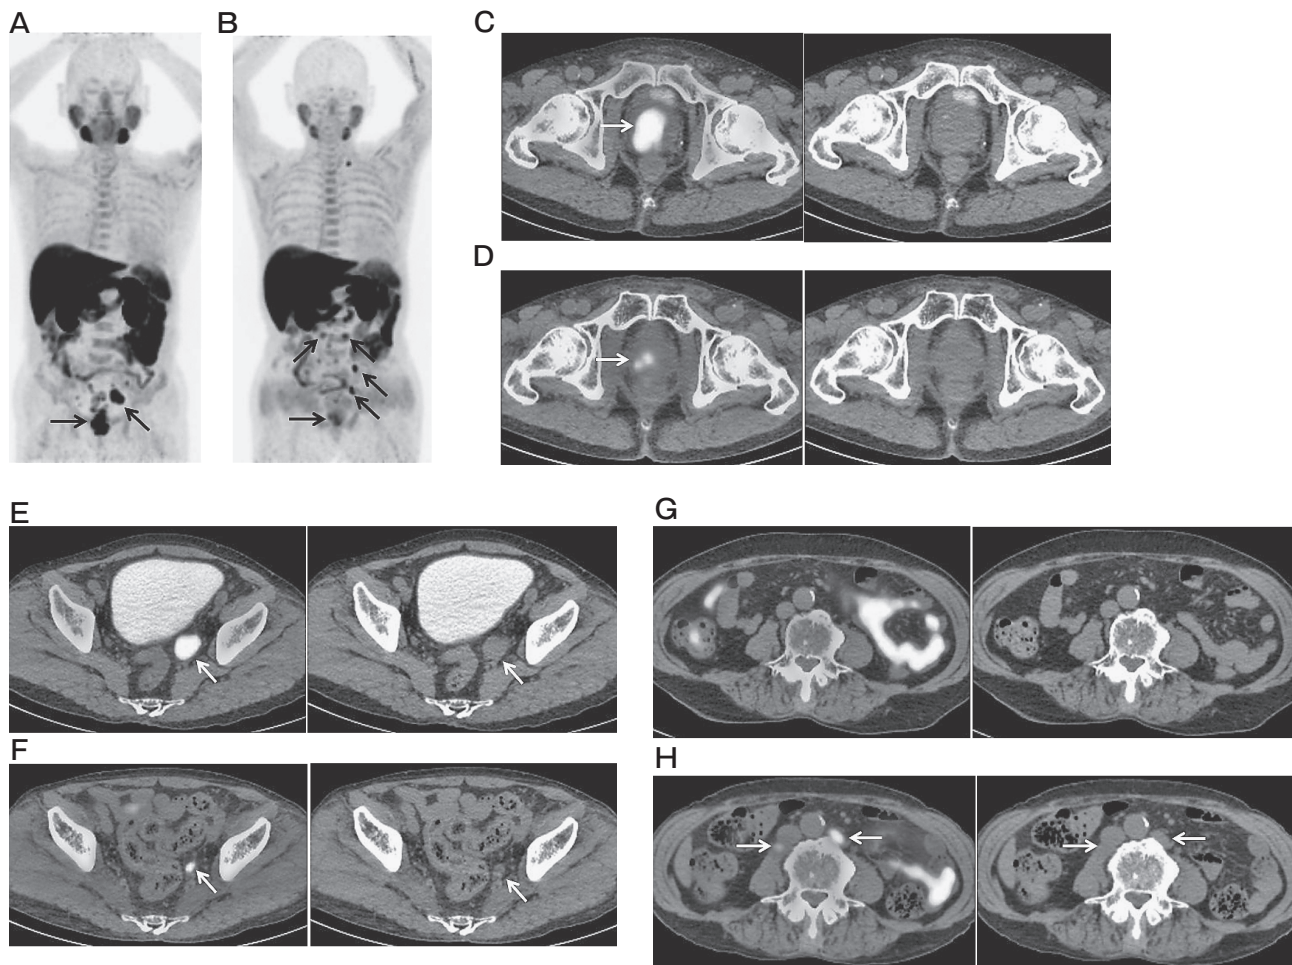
Representative case of a 79-year-old woman with prostate cancer treated by hormonal therapy. A, MIP from baseline ^{11}C -choline PET/CT shows two abnormal ^{11}C -choline uptakes in the pelvis (arrows); B, MIP from ^{11}C -choline PET/CT after radiation therapy and hormonal therapy shows multiple abnormal ^{11}C -choline uptakes in the pelvis and abdomen (arrows), reflecting progressive metabolic disease (PMD); C, Baseline ^{11}C -choline PET/CT and CT show intense ^{11}C -choline uptake (SUVmax, 8.27) in the prostate (arrow), suggesting viable residual primary cancer; D, ^{11}C -choline PET/CT and CT after radiation therapy and hormonal therapy show decreases in the abnormal ^{11}C -choline uptakes (SUVmax, 4.09) in the prostate (arrow), suggesting decreased tumor viability (partial metabolic response (PMR)); E, Baseline ^{11}C -choline PET/CT and CT show intense ^{11}C -choline uptake (SUVmax, 9.54) and swollen left internal iliac lymph node measuring 25×35 mm (arrow), suggesting viable residual lymph node metastasis; F, ^{11}C -choline PET/CT and CT after radiation therapy and hormonal therapy show decreases in the abnormal ^{11}C -choline uptake (SUVmax, 5.38) and size (8×12 mm) (arrow), suggesting decreased tumor viability (PMR); G, Baseline ^{11}C -choline PET/CT and CT on this slice show no abnormal findings; H, ^{11}C -choline PET/CT and CT after radiation therapy and hormonal therapy on the same slice as in G show the appearance of two para-aortic lymph nodes with abnormal ^{11}C -choline uptakes (arrows), suggesting new lymph node recurrence (PMD).
